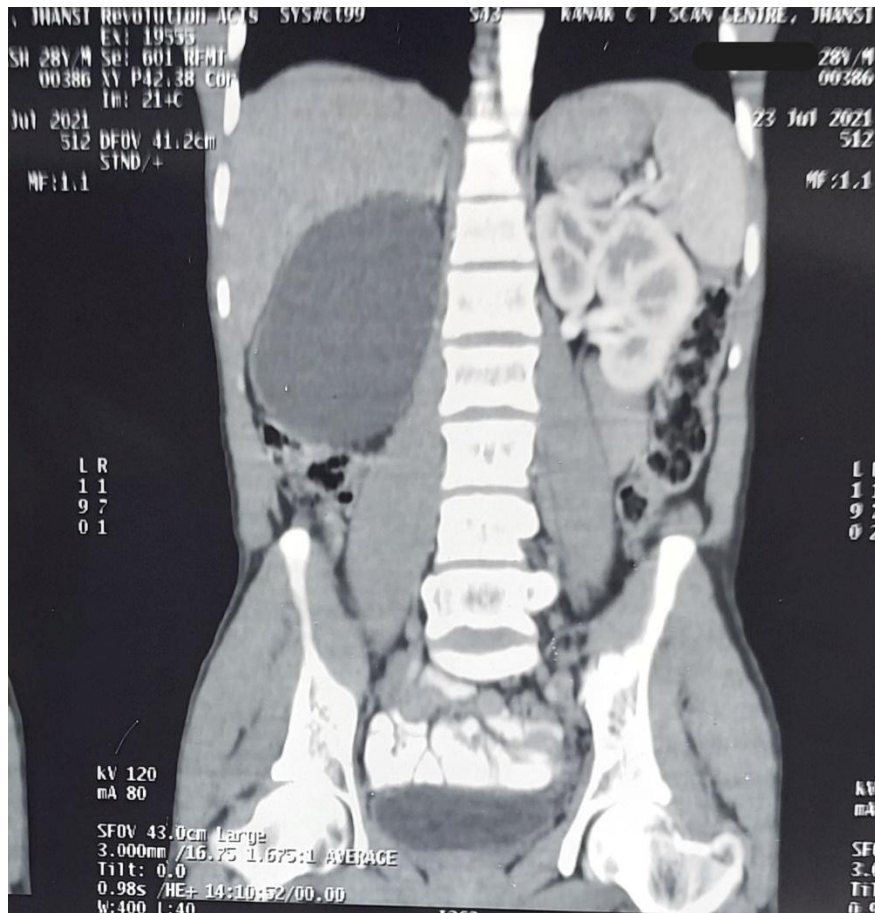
Coronal section of CT showing well defined cystic mass replacing Right Kidney
